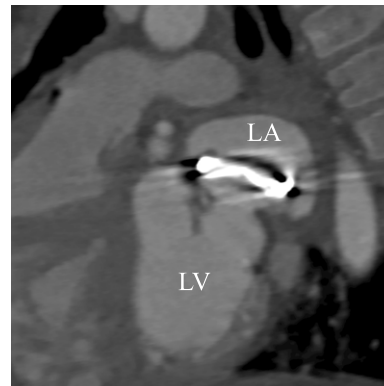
Pre-operative contrast-enhanced computed tomography. Subvalvular stenosis was observed. LA, left atrium; LV, left ventricle.
